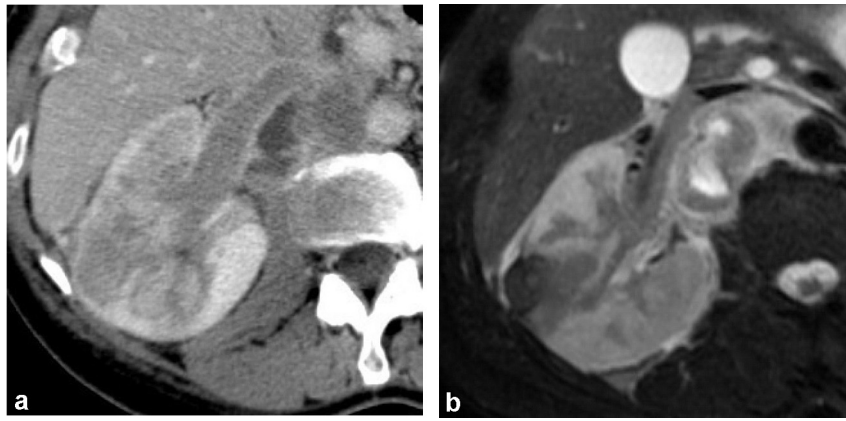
Infiltrating, sarcomatoid, papillary carcinoma with invasion of the renal vein and enlarged necrotic retroperitoneal lymph nodes; a: CT: tubular phase; b: MRI: T2 weighted image.
